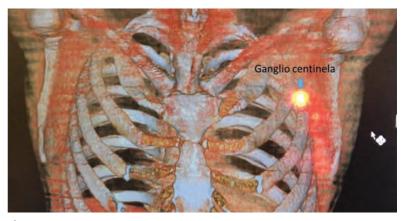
Misma paciente con adquisición SPECT/CT demostrando la ubicación del ganglio centinela con sus relaciones anatómicas cercanas.
